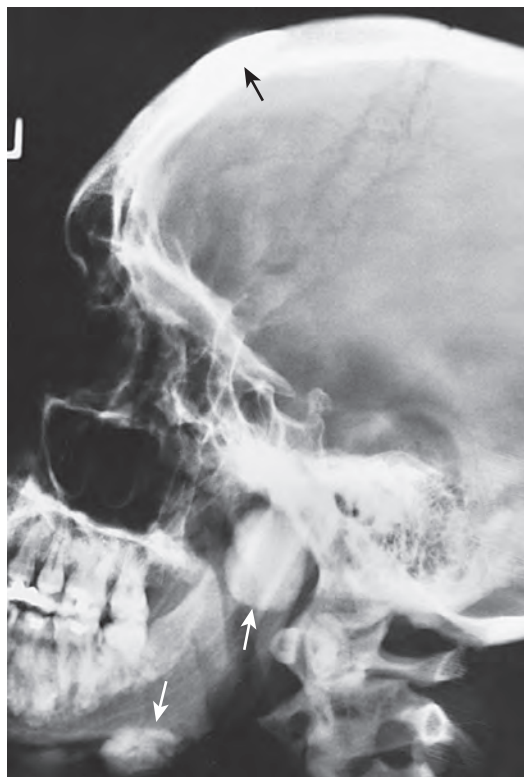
Multiple osteomas in a 23-year-old man with familial adenomatous polyposis syndrome. Lateral radiograph of the face and skull demonstrates two dense bony lesions (white arrows) arising from the mandible. A subtle lesion (black arrow) is also seen in the frontal bone.
